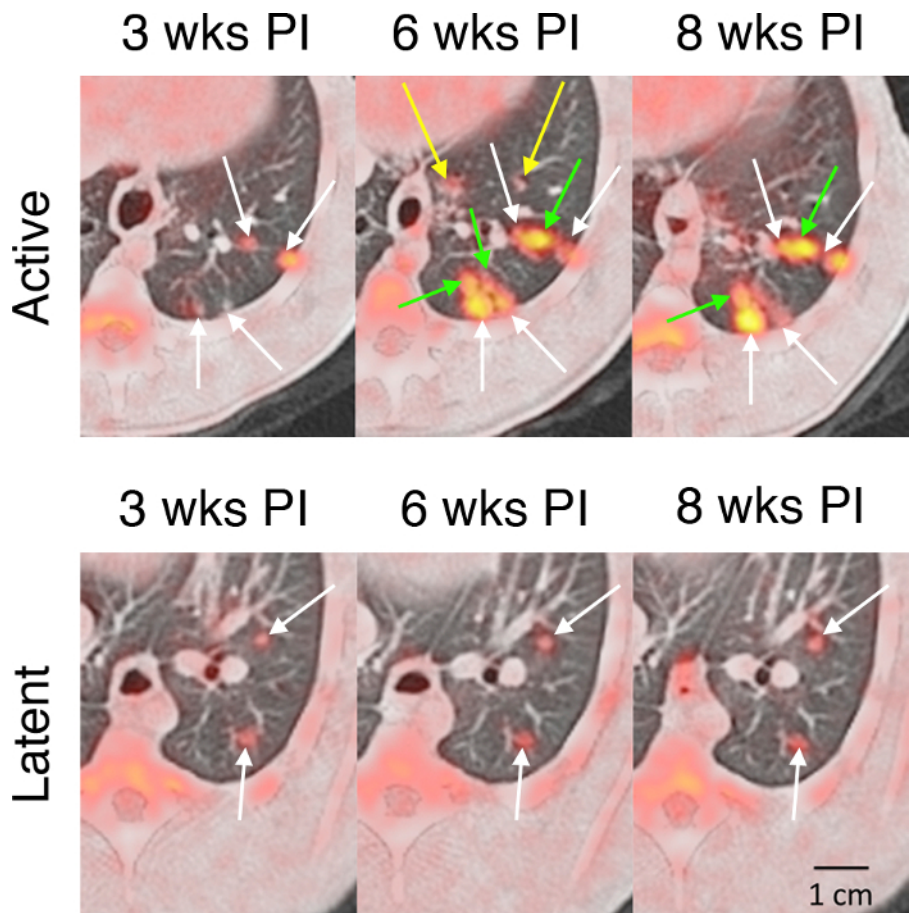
Serial FDG PET/CT Images Showing a Disseminating and Stable Pattern of Granuloma Evolution During the Course of Early Infection.
